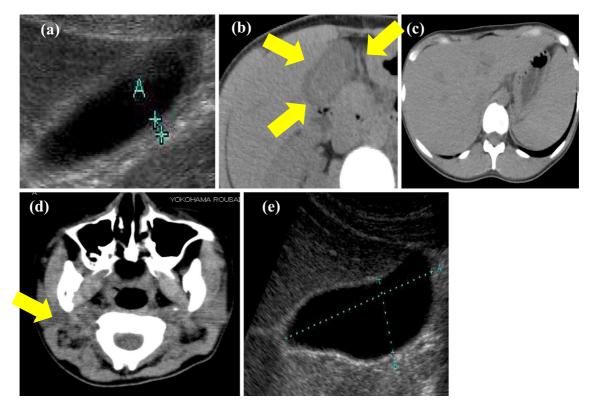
Ultrasonography and computed tomography (CT) images on admission. (a) Ultrasonography images of the gallbladder. (b, c) CT images of the gallbladder (arrows), liver, and spleen. (d) CT images of the cervical lymph nodes (arrow). (e) Changes in the gallbladder ultrasonography findings on day 26.
